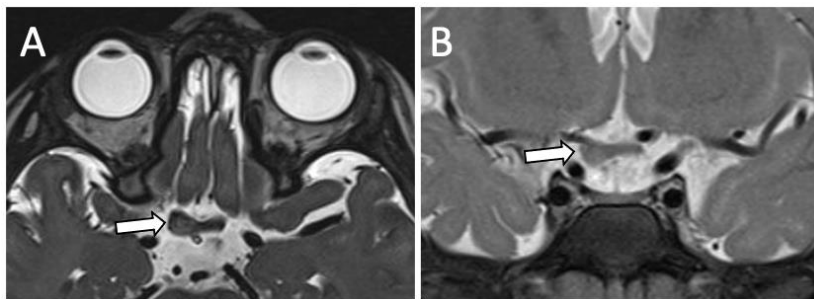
(a) Axial T2-SPACE image and (b) coronal T2-weighted image with fat saturation show focal thickening and faint T2 hyperintensity of the ipsilateral optic chiasm (arrows).
